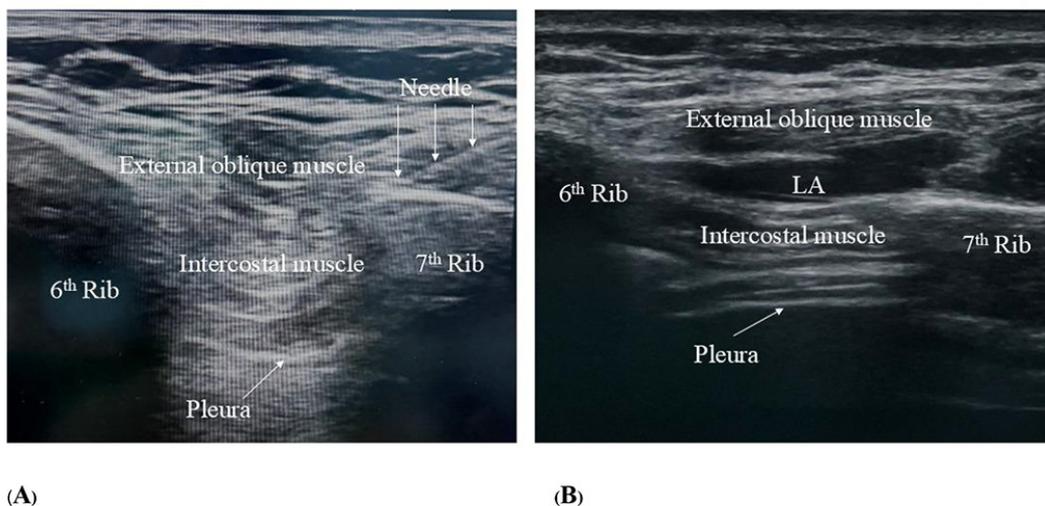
Ultrasound-guided EOI block, (A) In-plane needle advancement (white arrows) from caudad to cephalad between the 6th and 7th ribs, deep to the external oblique muscle overlying the seventh rib, (B) After injection, a hypoechoic layer of local anesthetic (LA) spreads beneath the external oblique muscle and above the intercostal muscle
